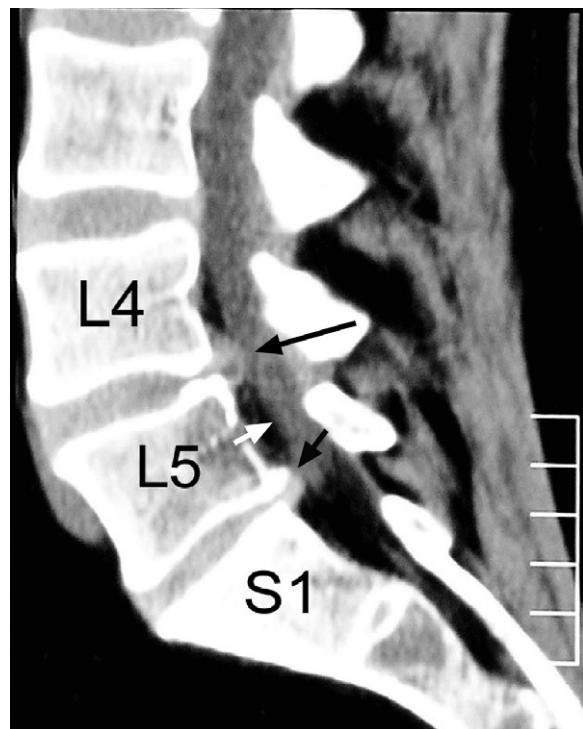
Lumbar spine CT sagittal image. Note: (i) the posterior disc protrusion at L4–5 level (long arrow), and (ii) the disc protrusion at L5–S1 (short arrow). Both the posterior disc protrusions indent the dural tube (white arrow) anteriorly.
